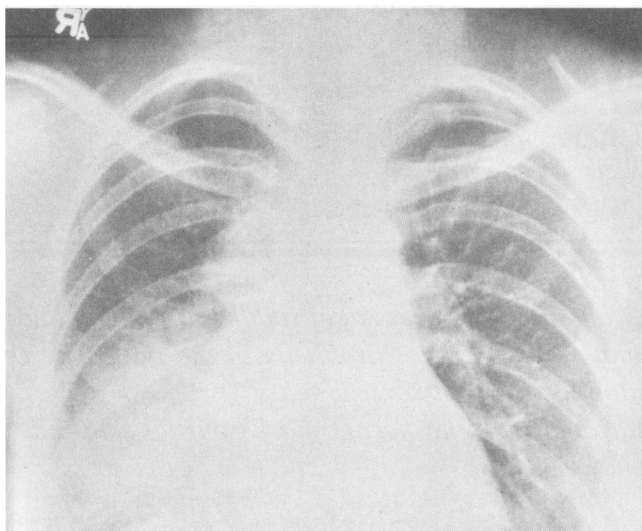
The chest x-ray film shows extension of the infiltrative process (shown in Figure 1) to involve most of the right middle and lower lobes.
